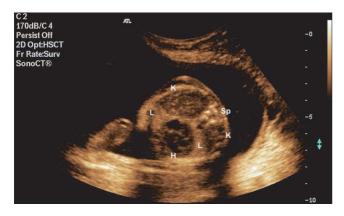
Transverse ultrasound image of the thorax with the kidneys (K) posterior to the lungs (L) and heart (H). Sp, spine.
